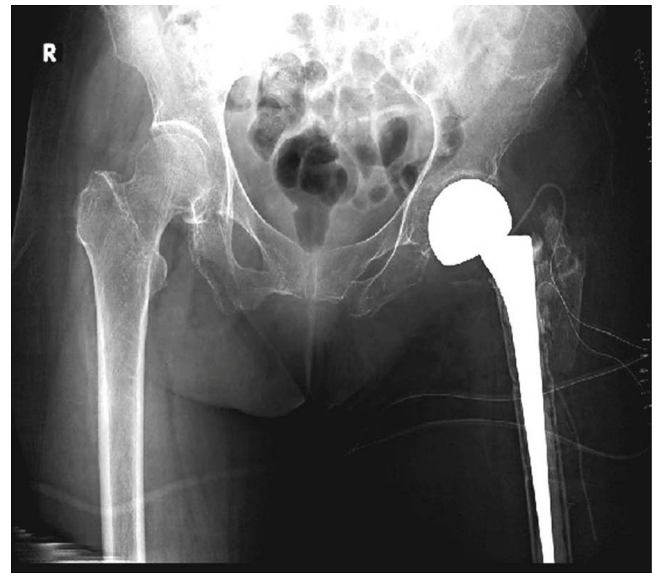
Initial plain radiograph of fracture.
